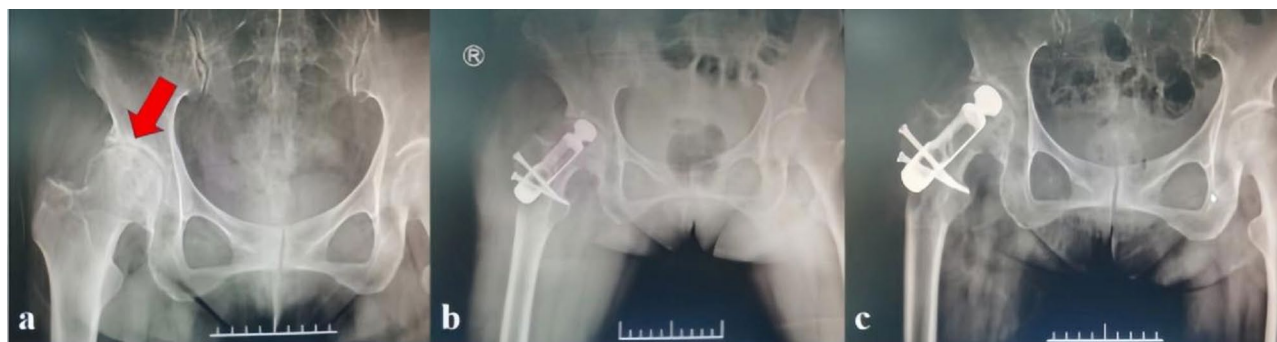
A 44-year-old woman with ARCO stage III of the right hip. (a) The preoperative X-ray. (b) Six-month follow-up. (c) Twelve-month follow-up
